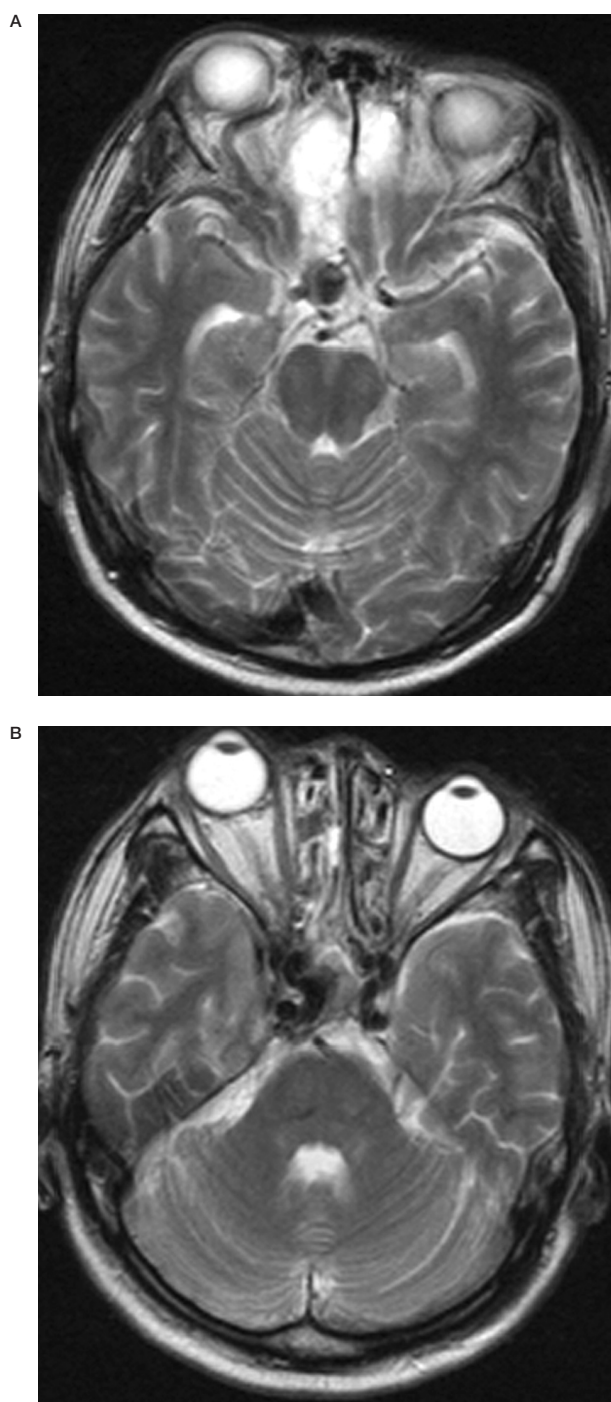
A,B) Axial T2-weighted magnetic resonance image shows a large saccular aneurysm (A) and abnormal flow void in the enlarged right cavernous sinus proximal (B).
